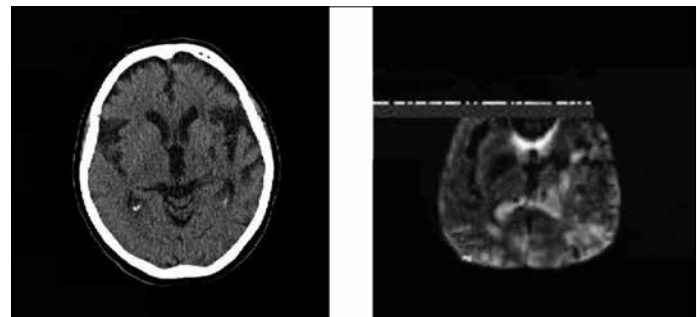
Restricted diffusion in the left temporoparietal lobe by diffusion MRI
